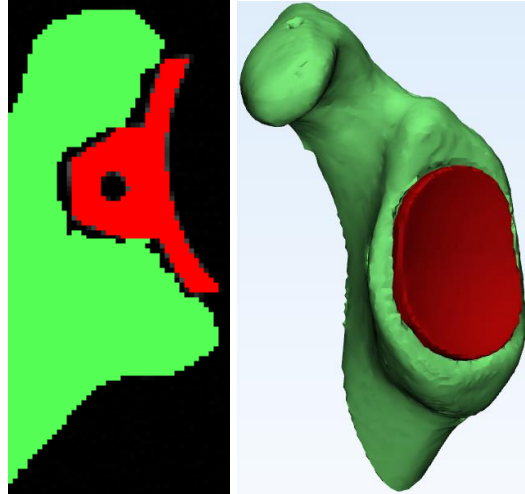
Post-Experiment CT scan of Robot Placement for Keeled Implant.
